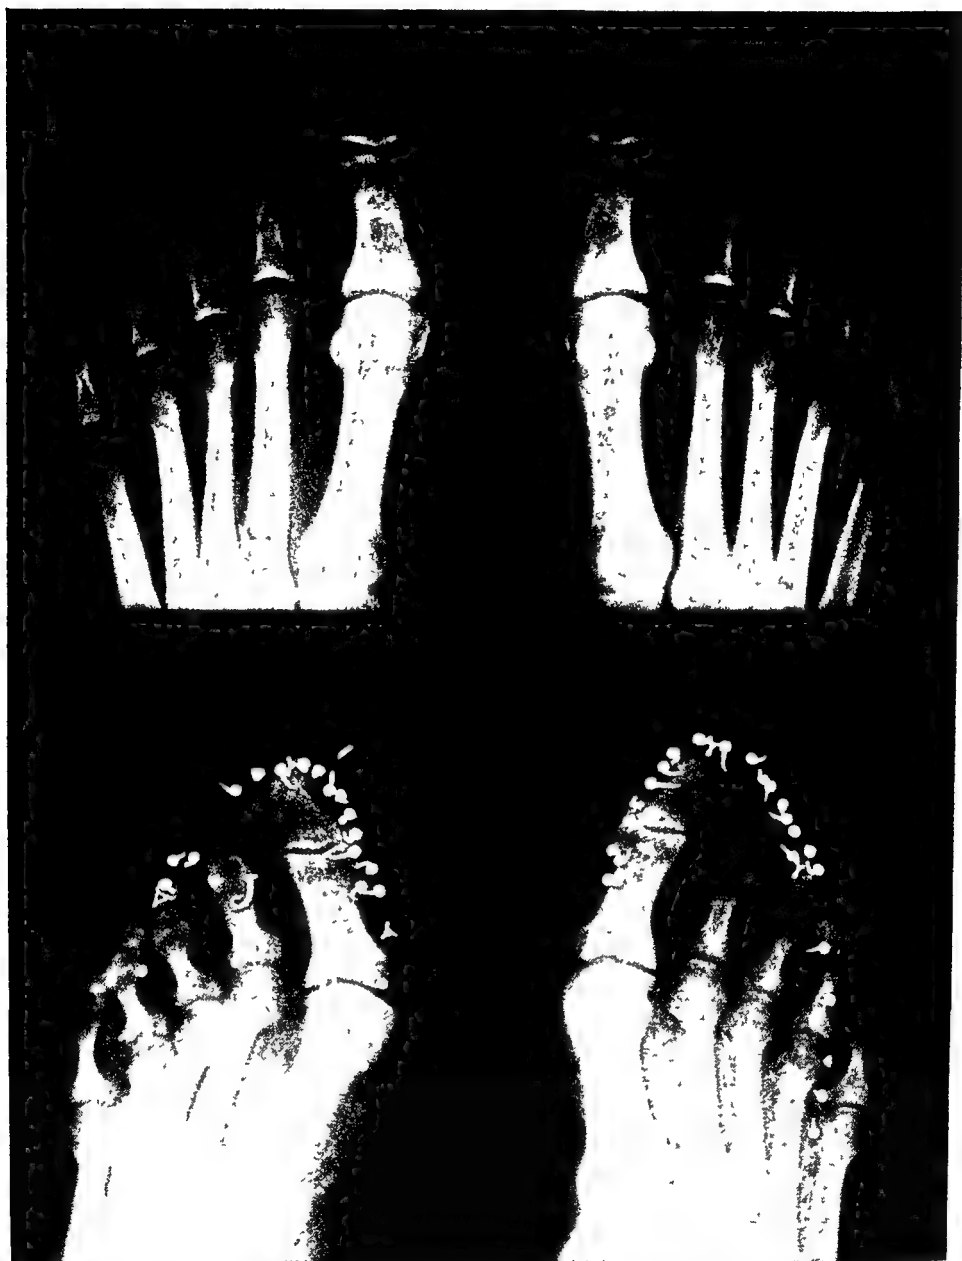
EXCRESCENCE EXPLORATORY ROENTGEN EXAMINATION Radiograph on 10 in x 12 in size. Toes in shoes on half Toes unshod but excrescences marked with zinc oxide on half.
